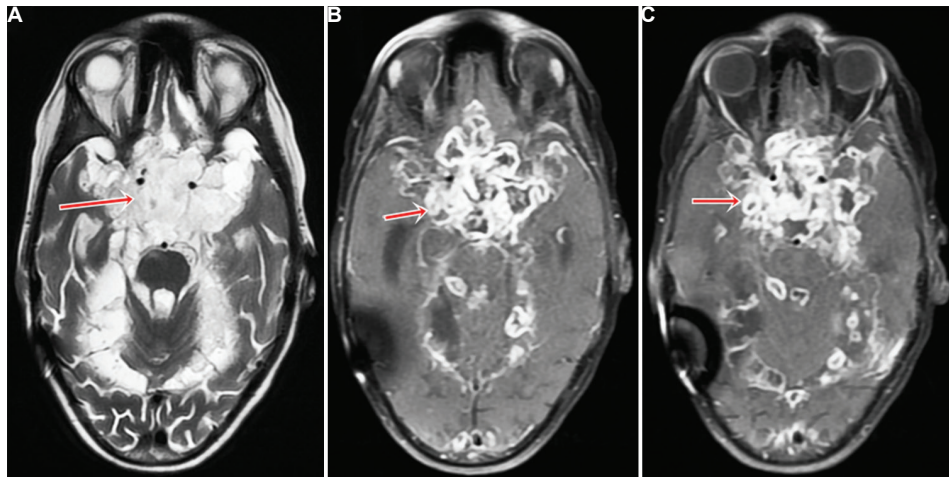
(A) T2-weighted magnetic resonance image of brain showing multiple lesions of varying intensity in the optochiasmatic region (red arrow). (B & C) Post-contrast T1 image showing multiple peripherally enhancing lesions in the optochiasmatic area (red arrow).
